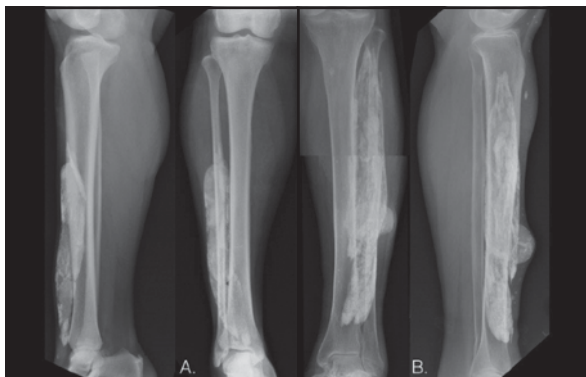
Antero-posterior and lateral X-ray images of both patients. Fusiform calcified lesions can be seen in the anterior compartment.
